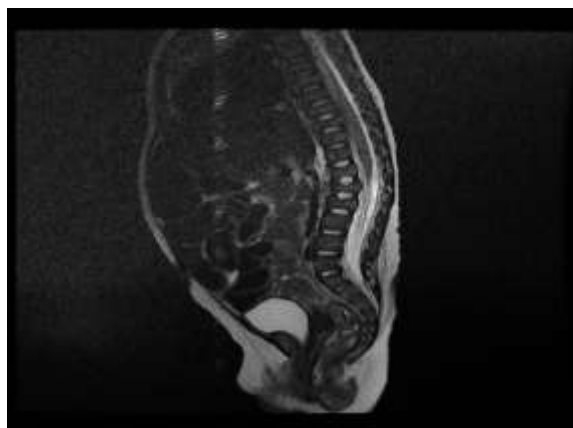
MRI spine showing loss of weight of the vertebral bodies T12, L1 and L2 with H shaped vertebra
